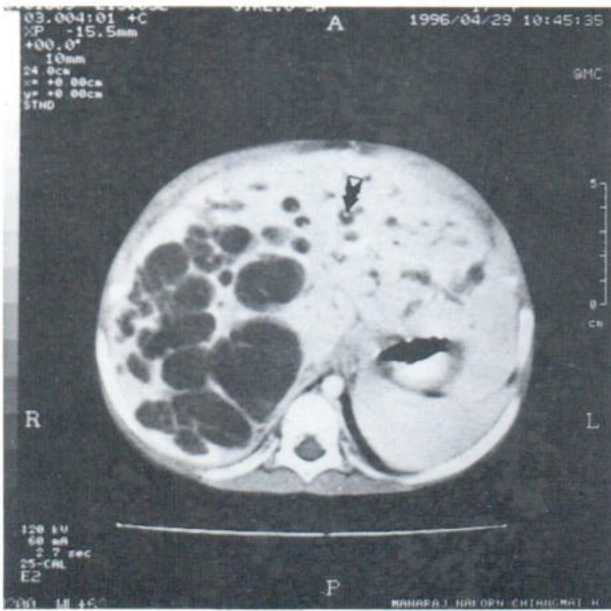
Contrast CT scan shows saccular dilatation of the intrahepatic bile ducts. Several tiny dots are seen in dilated bile ducts (arrow). Bridge formation (multiple septa) across the dilated bile ducts are seen in right hepatic lobe.
